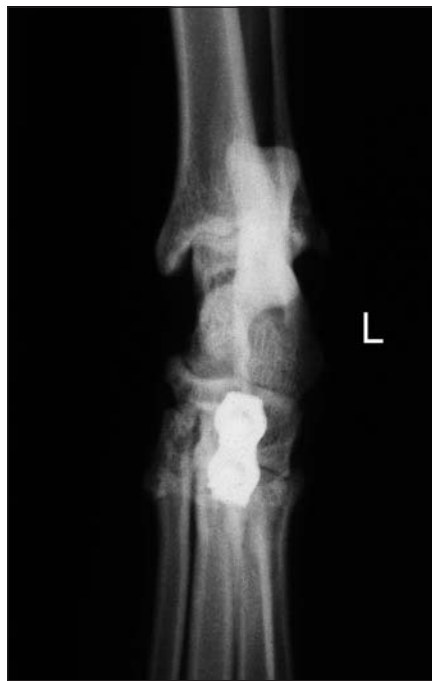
Medio-lateral view of the left tarsus, preoperative radiograph.
